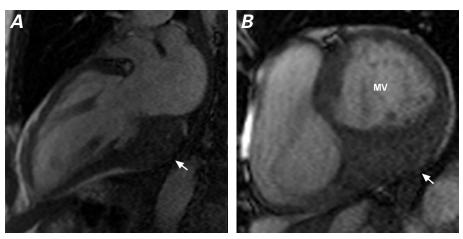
Steady-state free-precession magnetic resonance images in A) vertical long-axis and B) short-axis views show a mitral paravalvular mass (arrows).
